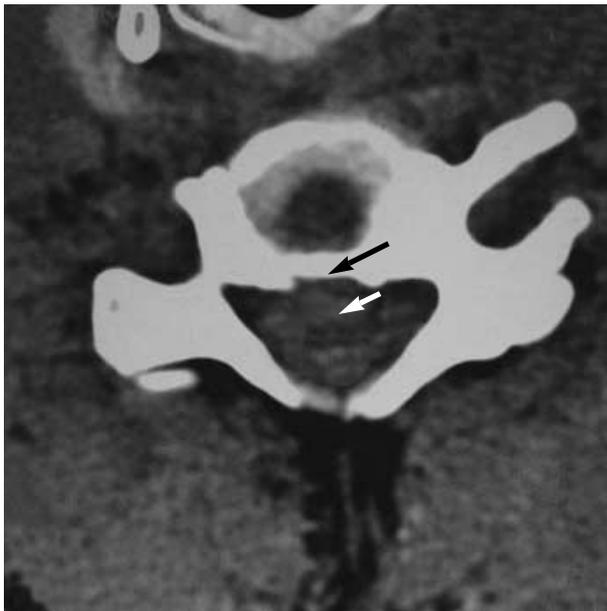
Cervical axial computed tomogram (CT) discloses resorption of the posterior margin of the upper C6 vertebra body (long arrow) and peripherally-enhanced epidural granulation (short white arrow).
